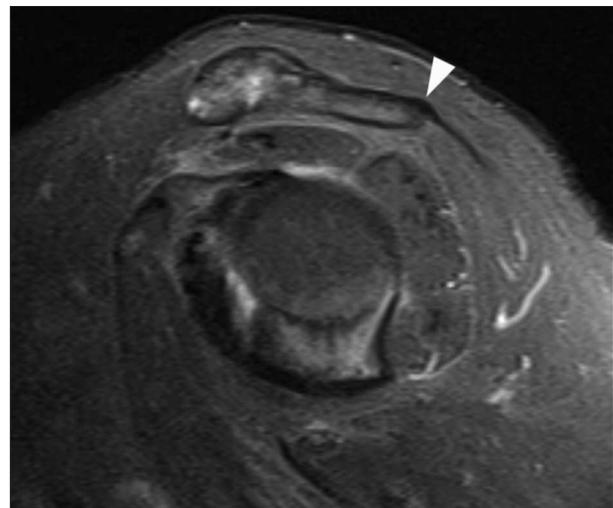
Deltoid acromial enthesopathy. Sagittal short-tau inversion recovery MRI shows a thickened and hypointense enthesis (arrowhead). Note the absence of hyperemic inflammatory changes.
